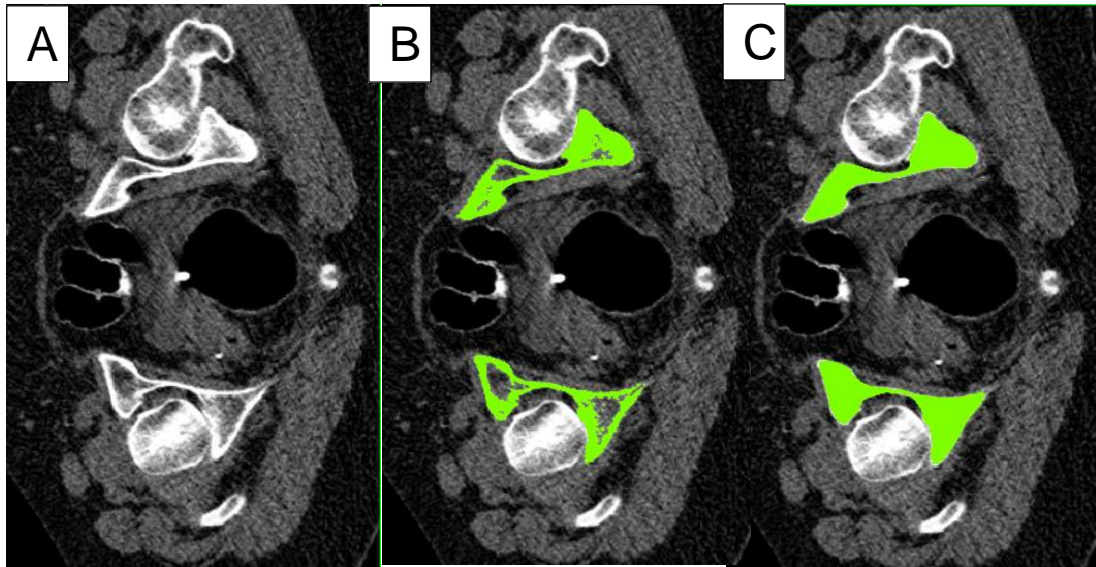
A transverse plane view of three 2D slices of the same CT scan image of one of the CT scans used in this study including all of the tissue shown as a greyscale in the Simpleware ScanIP software. A) The greyscale tissue with no highlighting. B) The same CT scan image after it has been highlighted by the greyscale range which highlighted cortical bone and demonstrates the inner cancellous bone which was not highlighted during this step. C) The same CT scan image following the manual highlighting of the cancellous bone in the pelvis.
